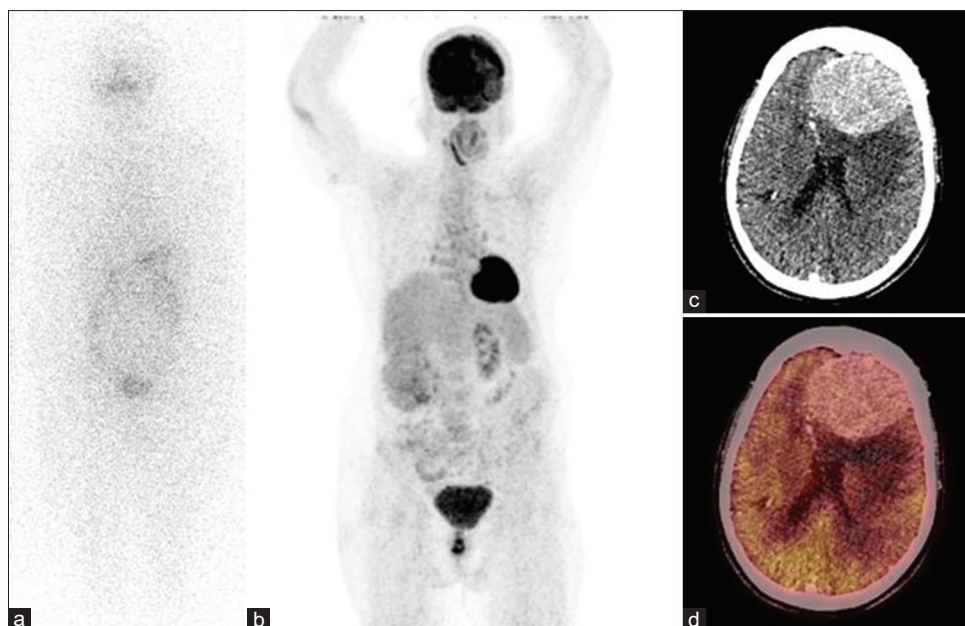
(a) I-131 scan showing no abnormal uptake, (b) F<sup>18</sup> FDG PET/CT MIP showing increased uptake in the brain, (c and d) Fused PET/CT and CT images showing F18 FDG avid lesion soft tissue lesion in the left frontal lobe. FDG PET/CT: Fluorodeoxyglucose positron emission tomography/computed tomography, MIP: Maximum intensity projection image
